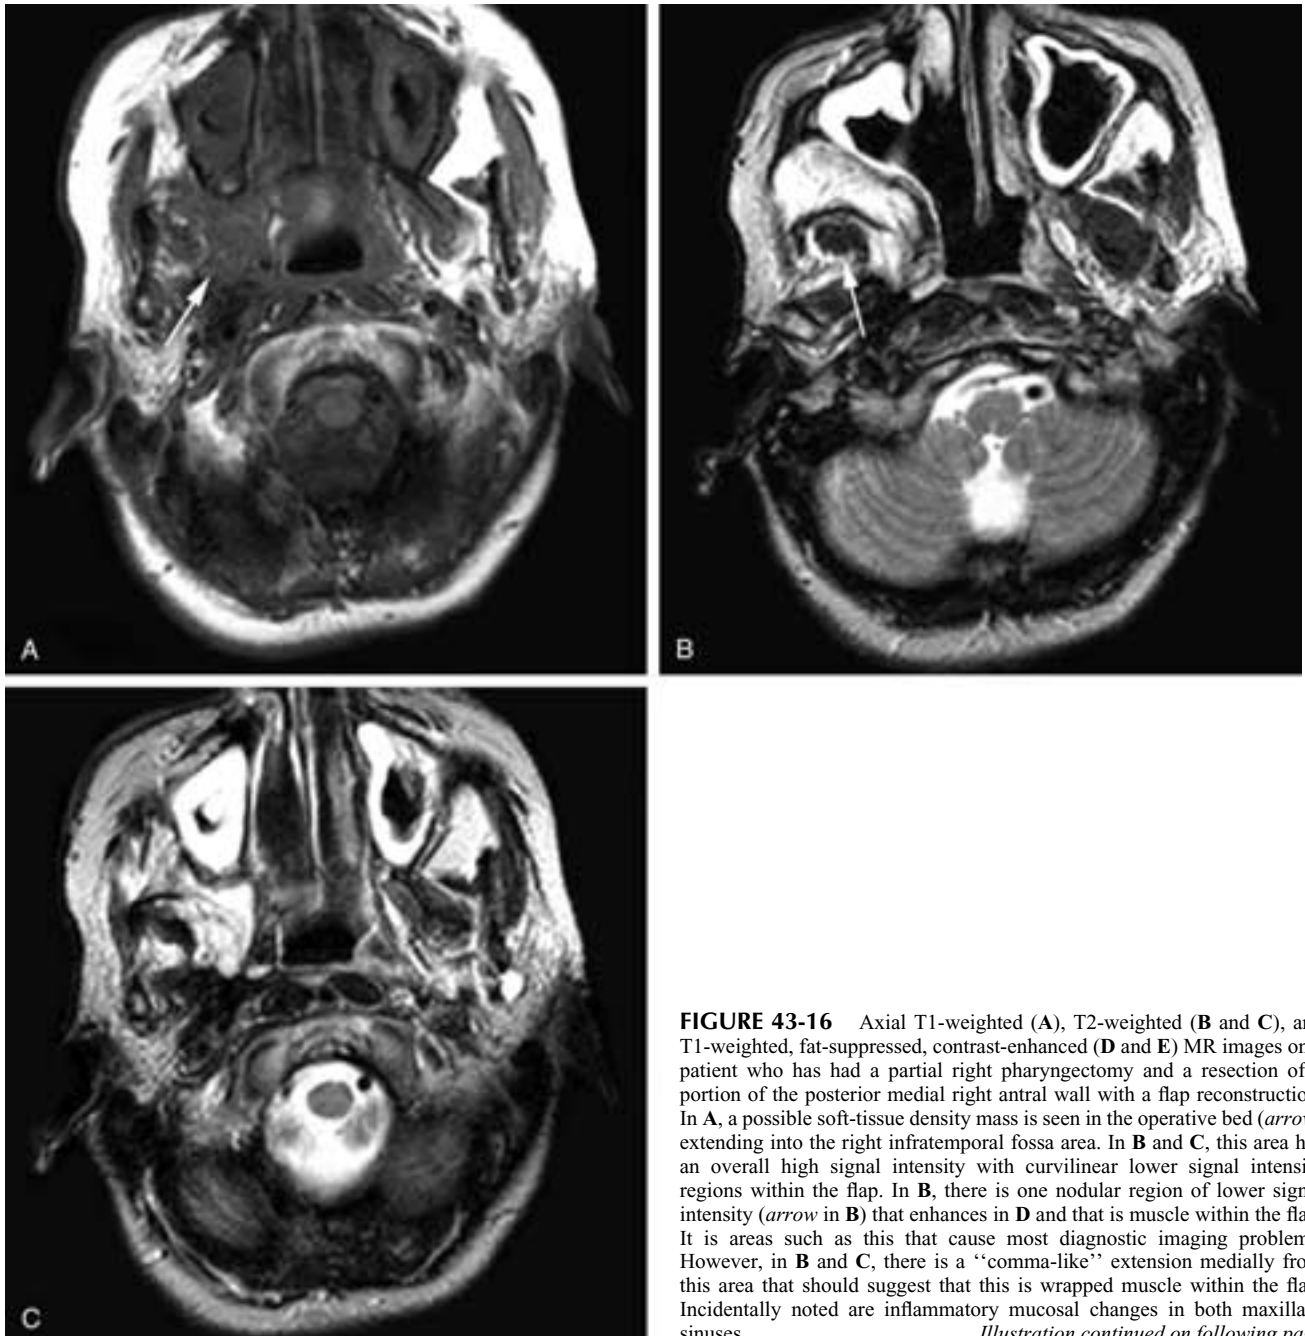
Axial T1-weighted (A), T2-weighted (B and C), and T1-weighted, fat-suppressed, contrast-enhanced (D and E) MR images on a patient who has had a partial right pharyngectomy and a resection of a portion of the posterior medial right antral wall with a flap reconstruction. In A, a possible soft-tissue density mass is seen in the operative bed (arrow) extending into the right infratemporal fossa area. In B and C, this area has an overall high signal intensity with curvilinear lower signal intensity regions within the flap. In B, there is one nodular region of lower signal intensity (arrow in B) that enhances in D and that is muscle within the flap. It is areas such as this that cause most diagnostic imaging problems. However, in B and C, there is a “comma-like” extension medially from this area that should suggest that this is wrapped muscle within the flap. Incidentally noted are inflammatory mucosal changes in both maxillary sinuses.
